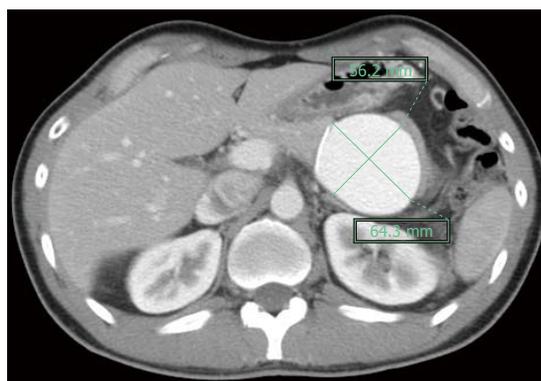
Abdominal computed tomography images demonstrating a splenic vein aneurysm approximately 56 mm × 64 mm in size.
